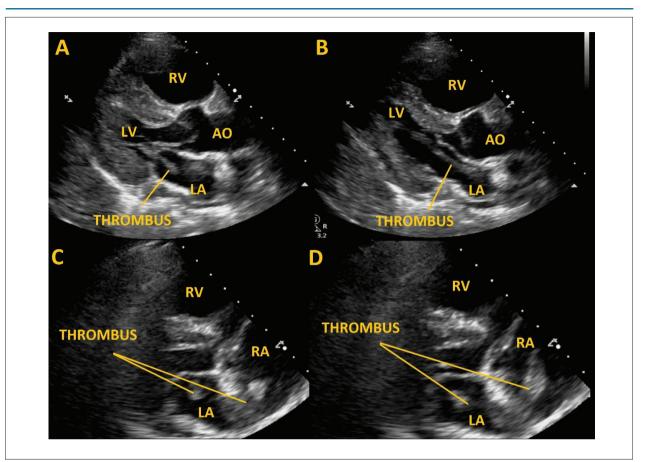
Transthoracic echocardiography. Panel A, B – parasternal long axis view showing large, serpiginous thrombus extending from the left atrium, through the mitral valve, into the left ventricle. Panel C, D – modified 4-chamber view showing enlarged right heart chambers and mobile thrombus extending from the right atrium to the left atrium, across an interatrial communication, through the mitral valve. AO: aorta; LA: left atrium; RA: right atrium; LV: left ventricle; RV: right ventricle.
